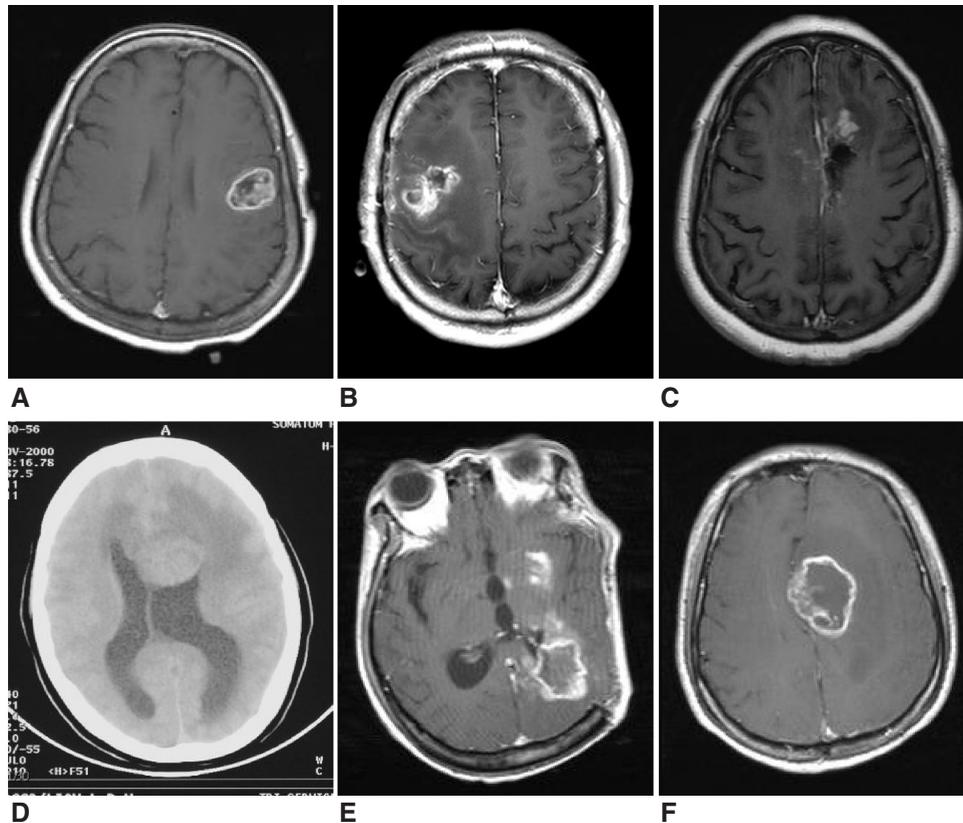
Computer tomography (CT) or magnetic resonance image (MRI) of the six patients (A-F) with gliosarcoma. The tumor was located in the right parietal area (case 1, A), left parietal area (case 2, B), right frontal area (case 3, C), bilateral frontal area (case 4, D), right occipital area (case 5, E), and the midline temporal area (case 6, F).
